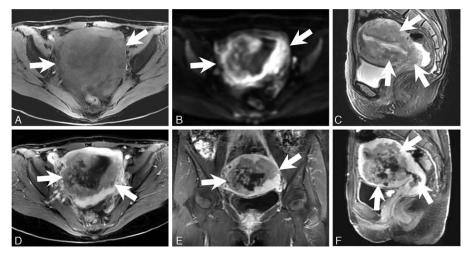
Transverse unenhanced T1-weighted image (A) showed an inhomogeneous hypointense mass (arrows) in the uterus. Corresponding transverse diffusion-weighted imaging (B) showed peripheral hypointensity of the mass. Saggital T2-weighted MR image (C) showed the mass (arrows) involved both the endomerium and myometrium, resulting in diffuse enlargement of the uterus. This mass showed relative hypointensity compared to the surrounding myometrium. On transverse (D), coronal (E), and saggital (F) enhanced T1-weighted images, this mass showed lower enhancement (arrows) than the surrounding myometrium. MR = magnetic resonance.
